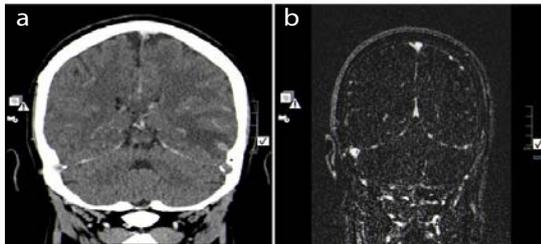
(a) Initial CT venogram and (b) MR venogram (from the following day) demonstrating no enhancement of the left transverse sinus in keeping with acute occlusive. Filling defect in the right transverse sinus on the CT venogram was focal and likely an arachnoid granulation.
